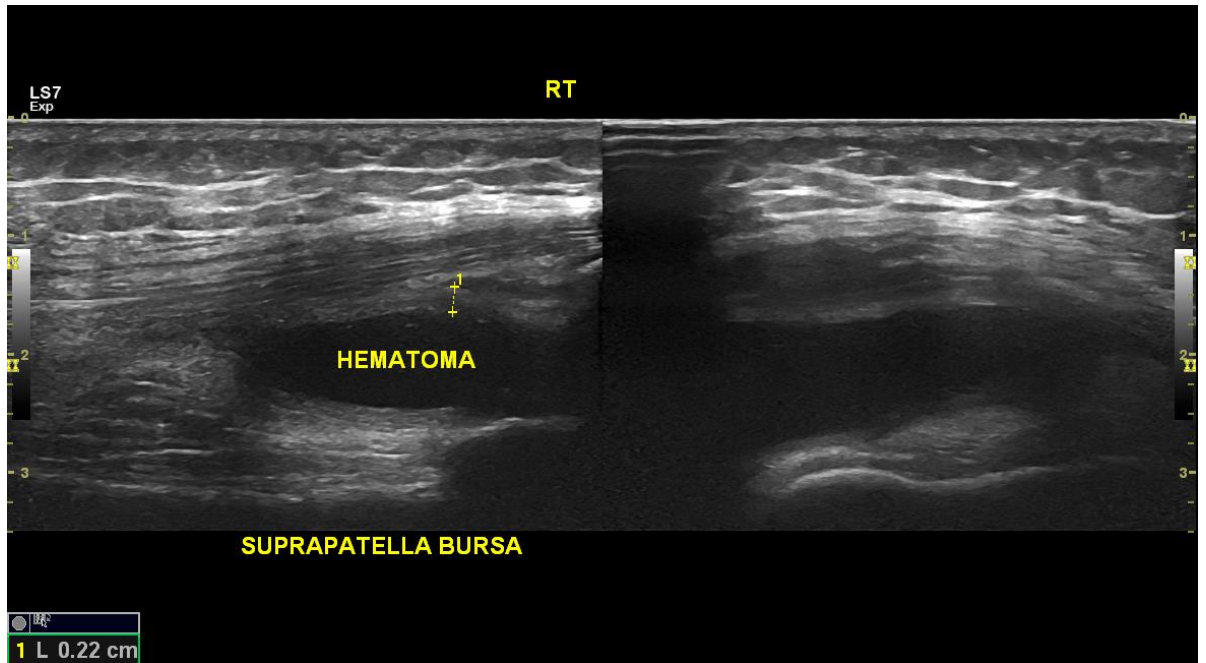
Sample image from ultrasound scanning during the study. Lateral (L3 lateral coronal) and Medial coronal (L2 Medial coronal).
